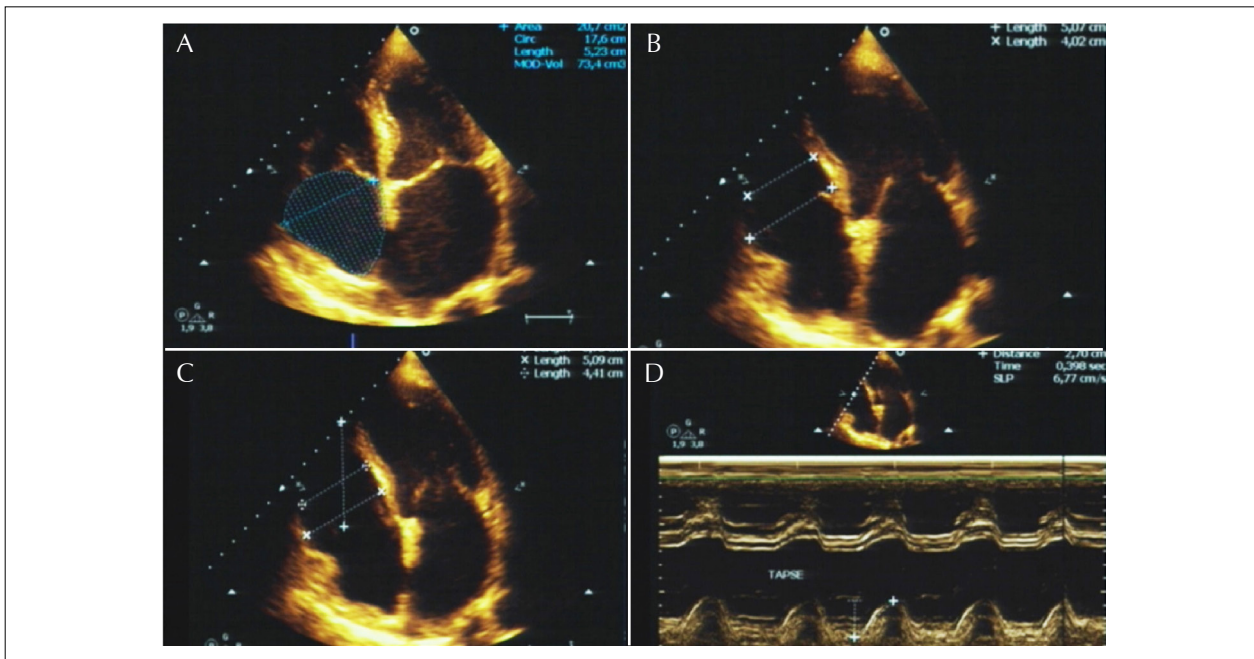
Echocardiogram showing on (A) Left top panel Four-chamber view of right atrial volume. (B) Right top panel: Two-dimensional measurements of basal and middle right ventricular diameters at end diastole. (C) Left bottom panel: Four-chamber view of two-dimensional measurements of basal, middle and longitudinal right ventricular diameters at end diastole. (D) Right bottom panel: Four-chamber apical view of unidimensional measure of tricuspid annular plane systolic excursion.
